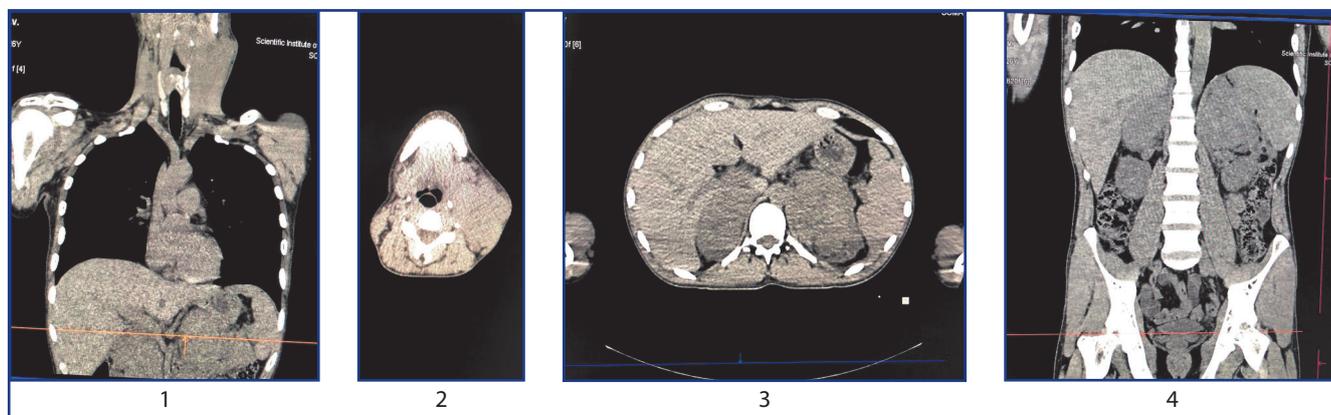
Multi-layer spiral CT before treatment. Patient M., 56 y.o.
